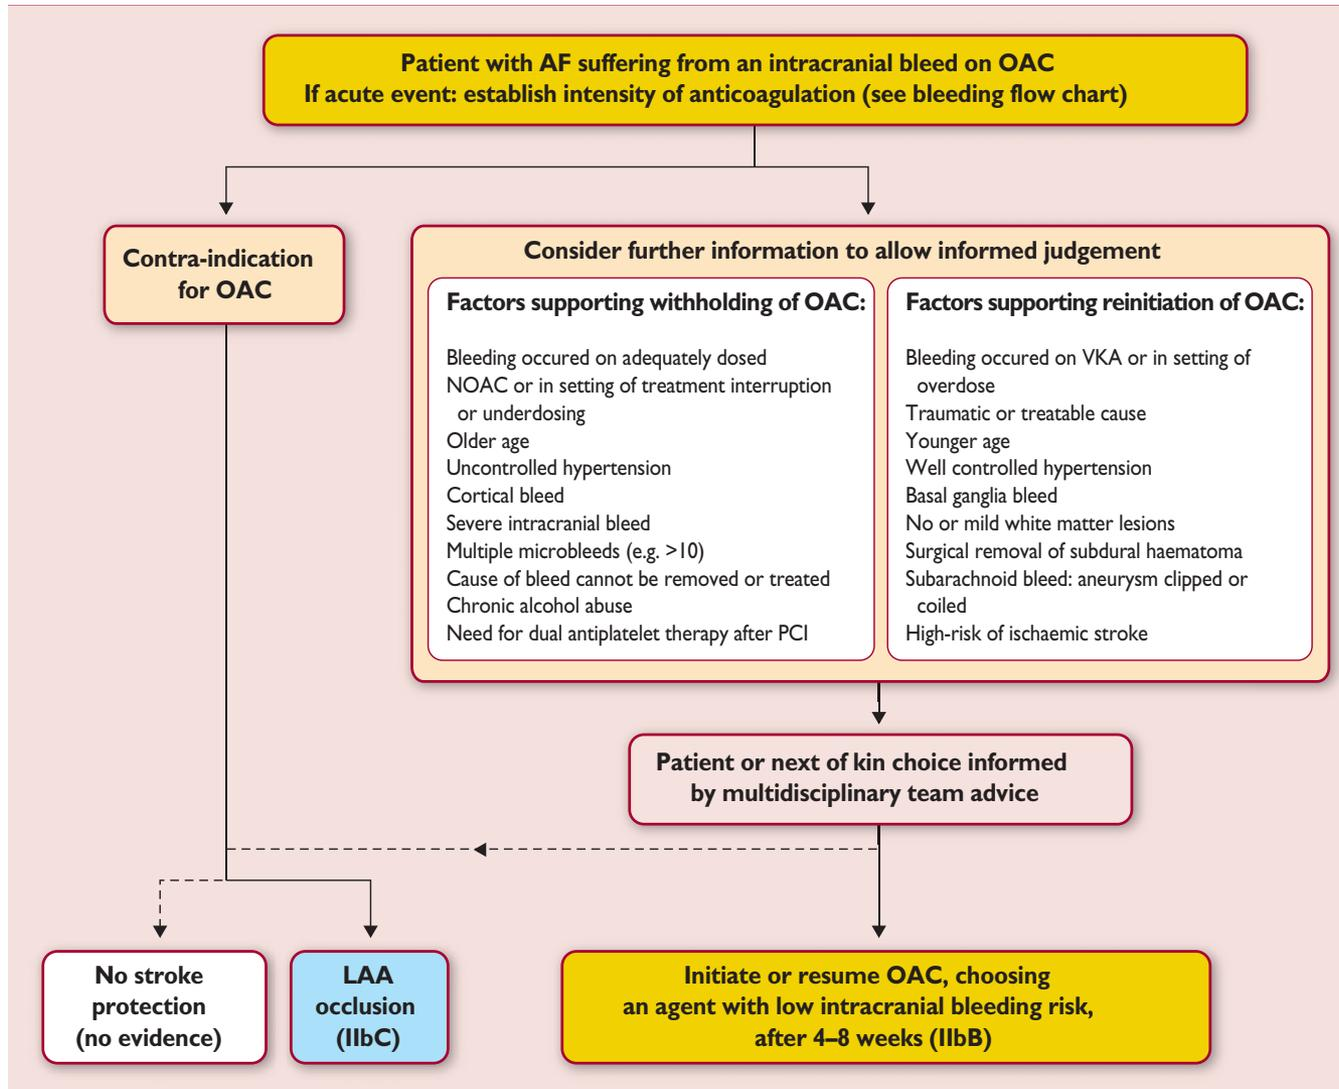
(Re-) initiation of anticoagulation post intracranial bleeding. [#]Without evidence; ideally include the patient in an ongoing trial. ^{*}Brain imaging (CT/MRI) should be considered before (re-)initiation of (non)-vitamin K antagonist oral anticoagulant.
